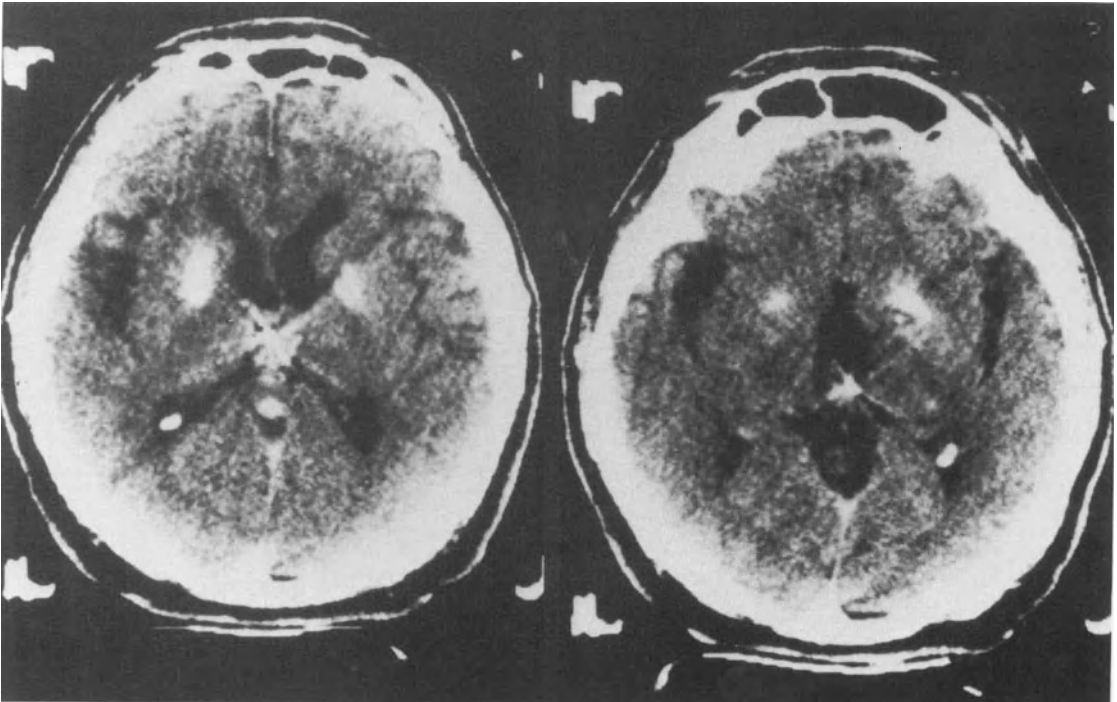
(*Left*) Intraoperative CT scan demonstrating the position of the stereotactic probe in the colloid cyst. (*Right*) Postaspiration CT scan demonstrating evacuation of the colloid cyst.
